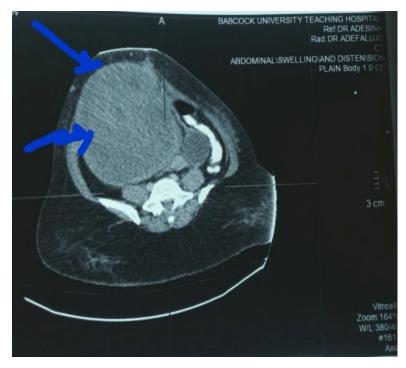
Computed tomography scanogram showing huge mixed density mass
